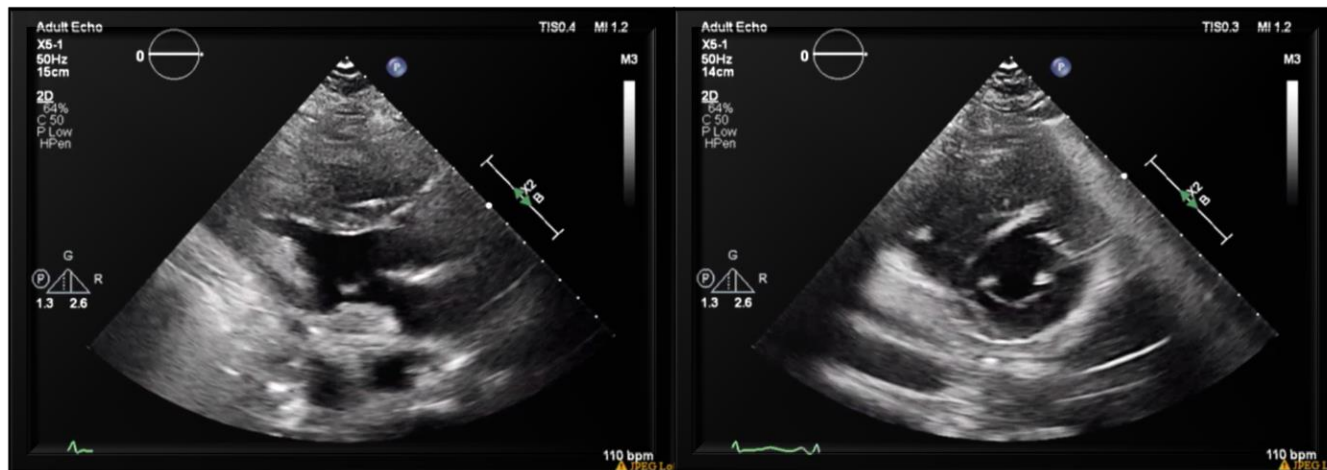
Post-transplant transthoracic echocardiogram. Post-transplant parasternal long axis and short axis views show a decompressed right ventricle and larger left ventricle internal diameter. Reported values: left ventricle ejection fraction 79%, left ventricle internal diameter during diastole 3.11 cm.
